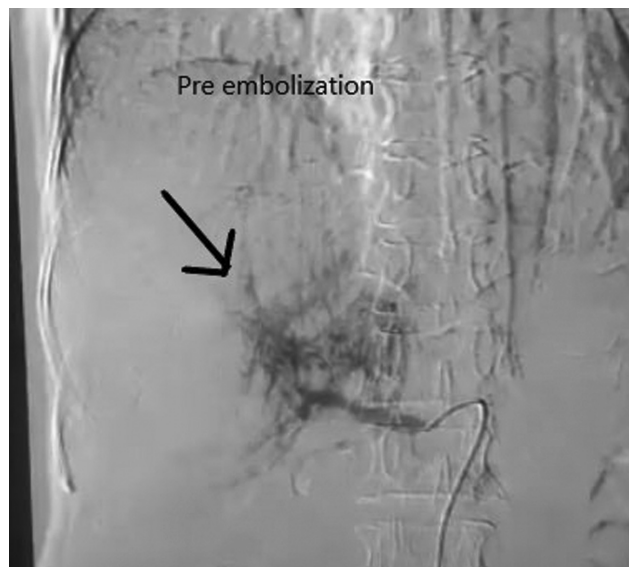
Computed tomography angiography showing tumor thrombus status before transarterial chemoembolization done using doxorubicin and lipiodol.
